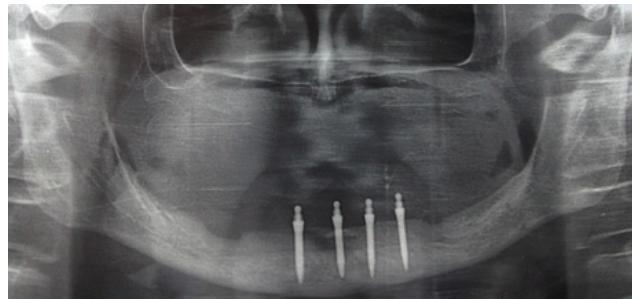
Orthopantomography with placed implants
